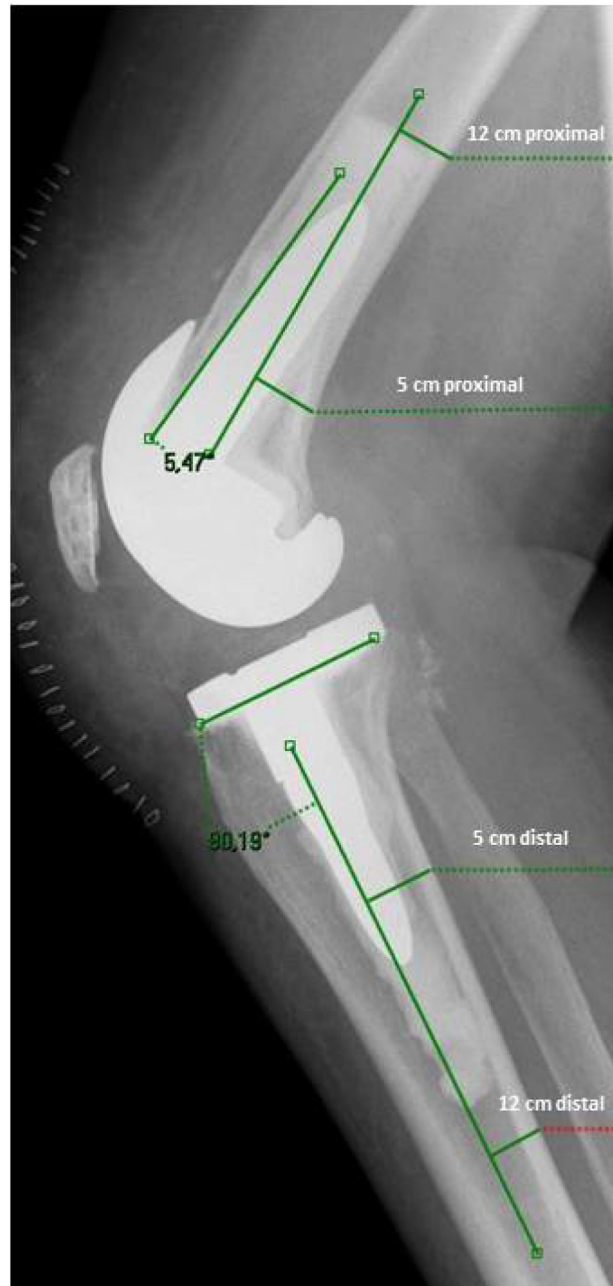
The flexion–extension of the femoral component was measured with respect to the sagittal femoral anatomic axis (SFAA). The SFAA bisects a trapezoid best fit to the distal femoral diaphysis and corresponds to the portion of the femur typically imaged by a lateral radiograph of the knee. The tibial slope was measured with reference to the anatomical axis of the tibia.
